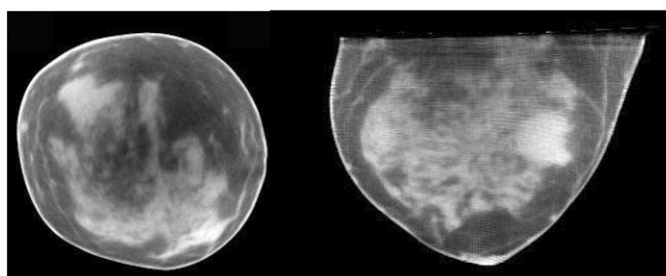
Reconstructed CT (left) coronal and (right) transverse image slices of human subject volunteer.
